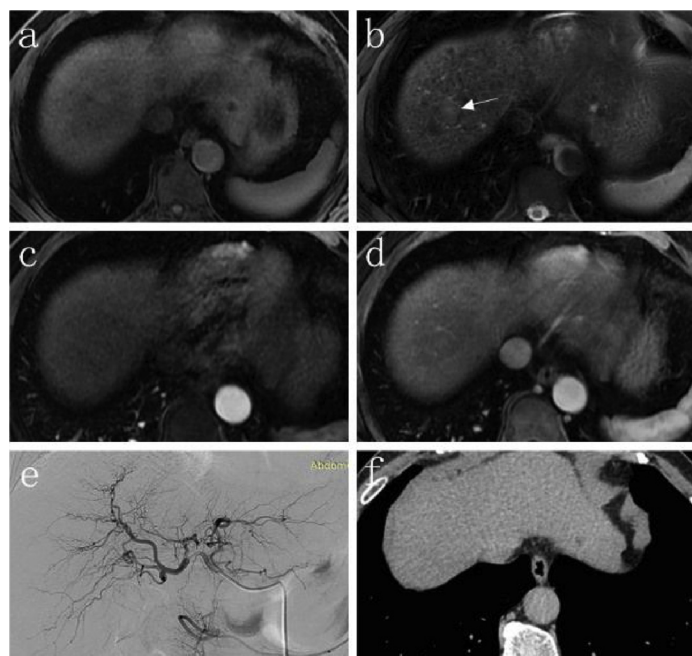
LR-3 nodule and TAE outcome. An obscure nodule in segment 8 showed iso intensity on T1WI (A) and mild hyper intensity on T2WI (B). T1-weighted post-contrast demonstrated iso-enhancing relative to liver (C, D). This nodule was categorized in LR-3. DSA findings was negative (E), diagnostic and prophylactic embolization was merely performed. CT 6 weeks later showed absence of lipiodol deposits (F).
